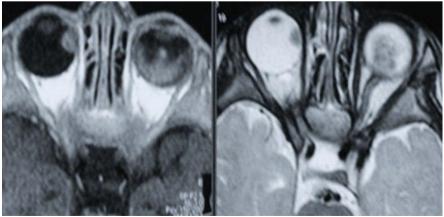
Showing MR images of a case with retinoblastoma
